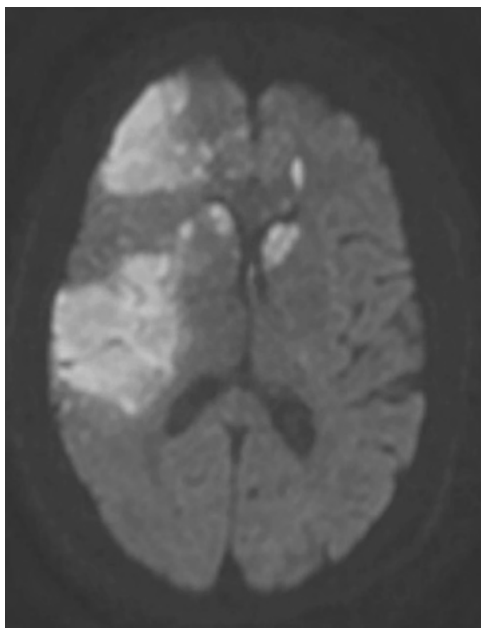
Brain MRI: right fronto-parietal cortex, caudate and lenticular nucleus and left caudate nucleus restricted diffusion
